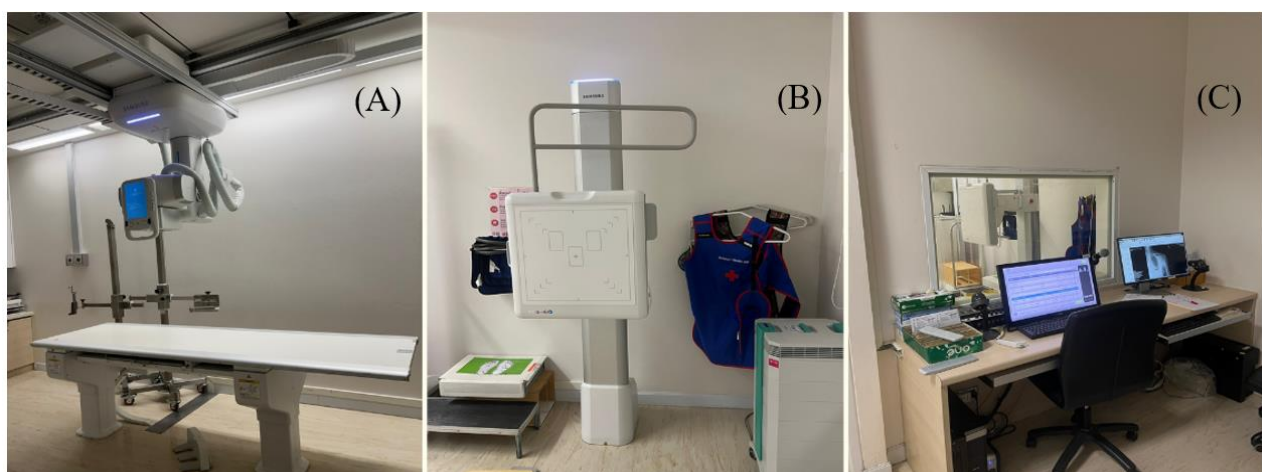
X-ray machine (including X-ray tube and bed) (A), standing detector (B), and work station (C), which are located at KCMH.
